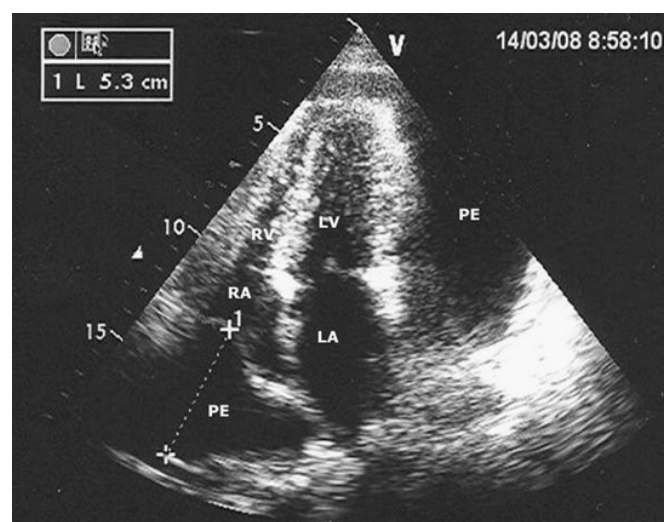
Transthoracic echocardiography from apical 4-chamber view demonstrating large pericardial effusion and right atrial collapse (LA: left atrium, LV: left ventricle, RA: right atrium, RV: right ventricle, PE: pericardial effusion).
